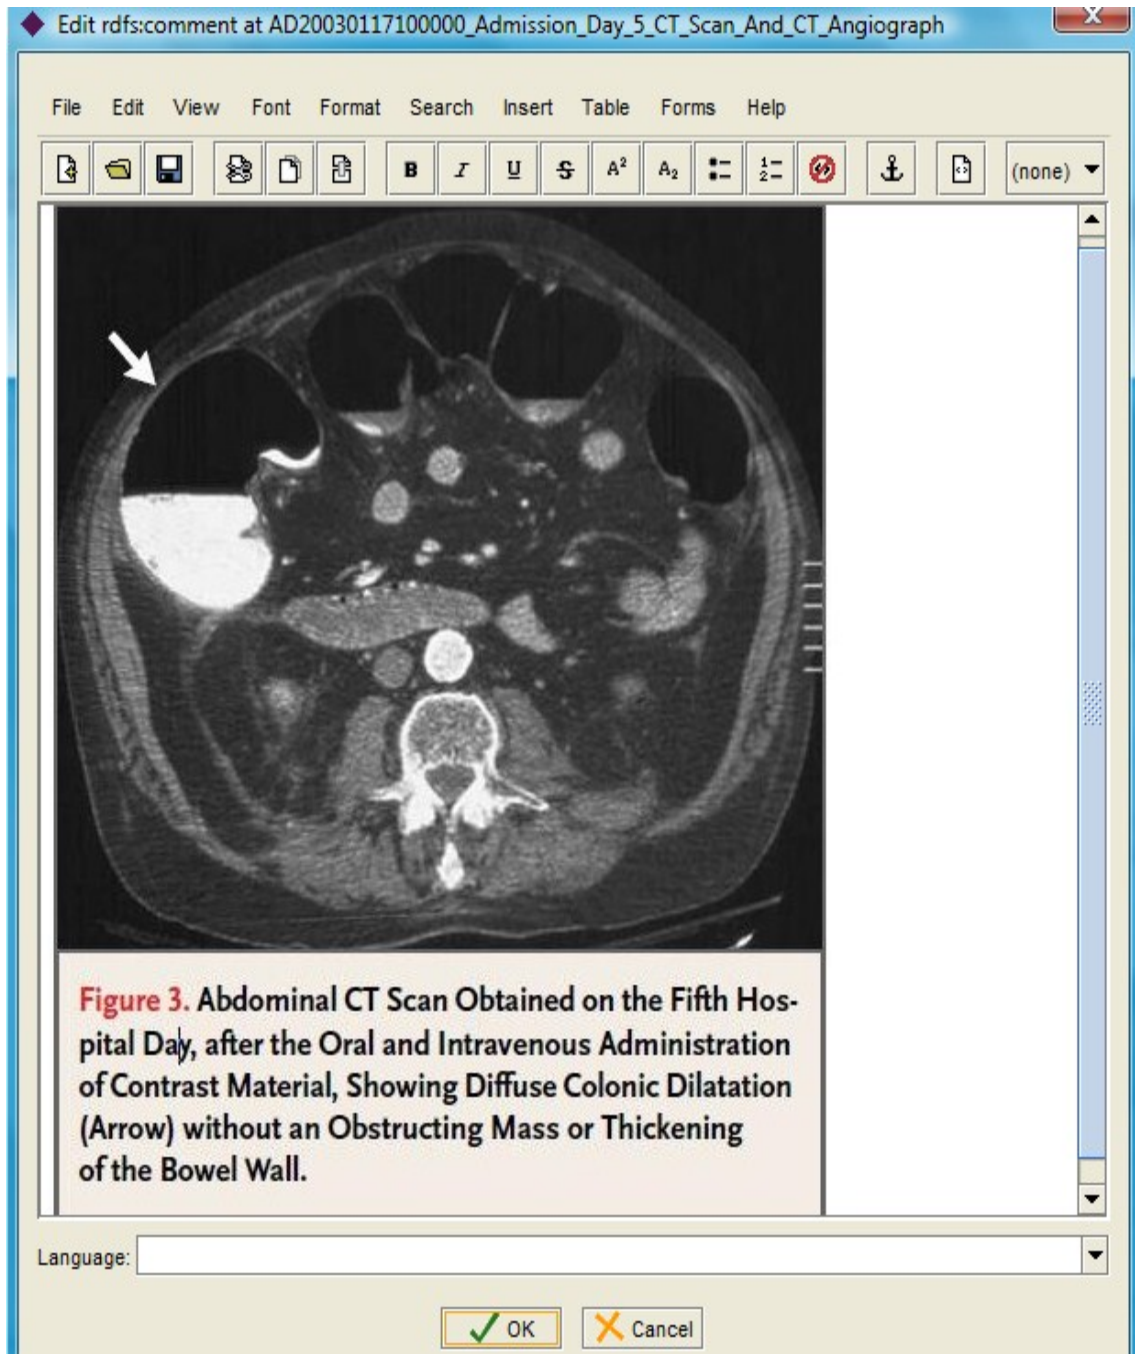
Admission day 5 image of Abdominal CT Scan captured via RDF comment in CD- EMR Ontology. Image taken from [113]
